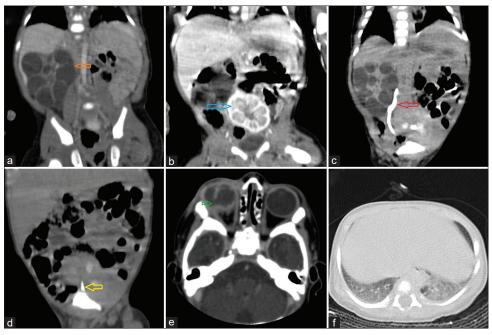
(a) computed tomography (CT) plain coronal view shows right enlarged kidney (average HU 30) with cysts of variable size with no communication between them (Orange arrow). (b) CT coronal plane view shows the left kidney at the level of the upper border of L3 to the lower border of the L5 vertebra, suggestive of the left ectopic kidney (Blue arrow). (c) Right kidney shows mild parenchymal enhancement (average HU 100) with contrast filling in the ureter on the delayed scan (Red arrow). (d) CT coronal image shows contrast filling in the left ureter in the delayed phase. (Yellow arrow). (e) CT axial section of the orbits discovered defect in the lateral globe wall on the temporal side (Green arrow), which allowed ocular contents to protrude. (f) Visible chest CT axial image shows areas of air space opacification in basal segments of bilateral (Left>Right) lower lobes with mild adjacent parenchymal atelectasis.
